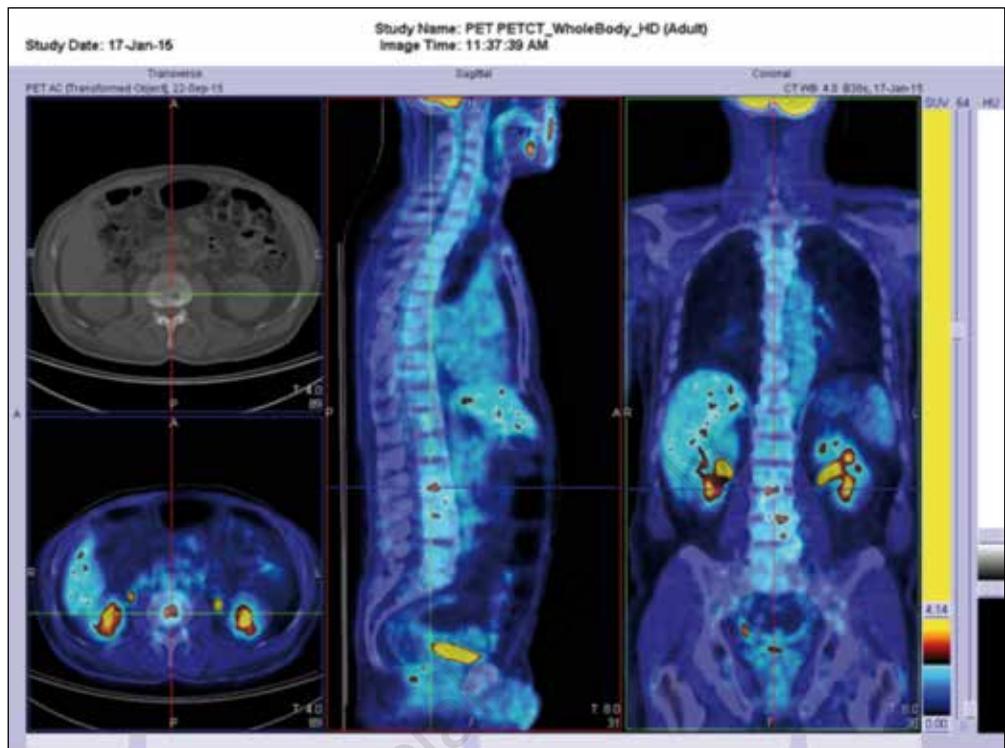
18F-FDG-PET/CT showed an increased metabolism at the level of the spinal space of L2-L3 L3-L4.
